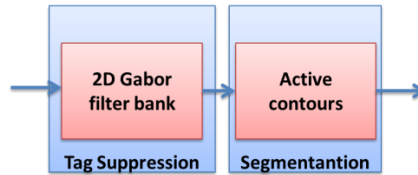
Block scheme for segmentation in t-MRI using the strategy proposed in [77].
